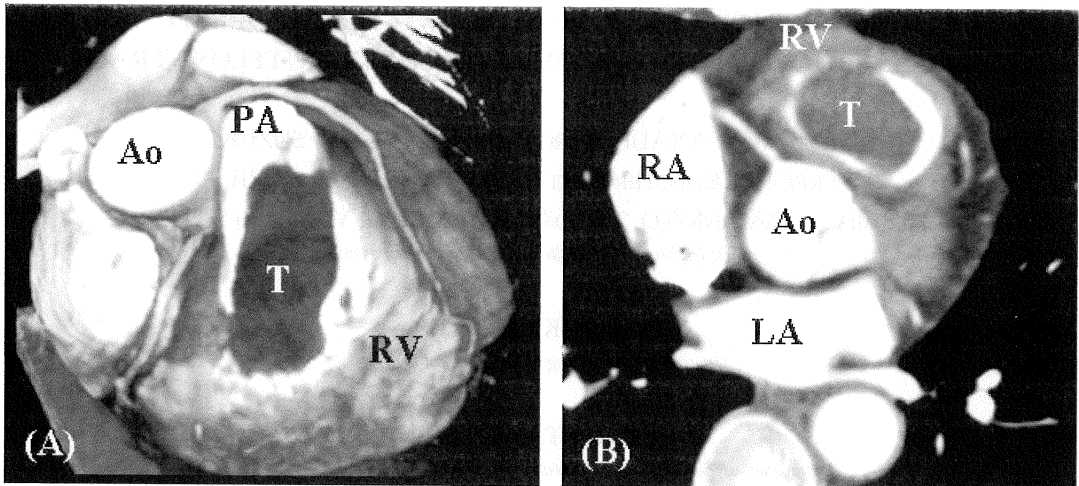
(A) Volume rendering cardiac images of MSCT. Massive cardiac myxoma occupying right ventricular outflow tract, and protruding into the main pulmonary artery. (B) Axial transverse reconstruction (multiplaner reformation: MPR) CT of the right ventricular outflow. Note the narrowing of right ventricular outflow tract by cardiac myxoma. Ao= ascending aorta, PA= pulmonary artery, RV= right ventricle, RA= right atrium, LA= left atrium, T= tumor mass.
